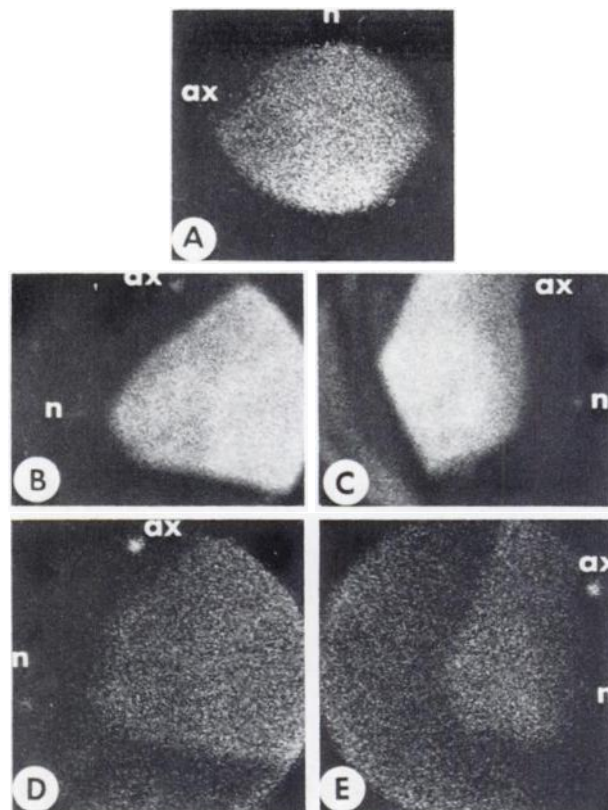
Normal craniocaudal (A), lateral (B), and medial (C) $^{99\text{m}}\text{Tc}$ -pertechnetate breast scintigraphy demonstrate homogeneous radionuclide activity. Gallium-67-citrate lateral (D) and medial (E) views of same breast show uniform accumulation. There is often relative increase in radioactivity close to chest wall in all views. Sharp delineation in medial views is caused by lead shielding against chest wall. Axillary and nipple ^{57}Co markers are evident.
